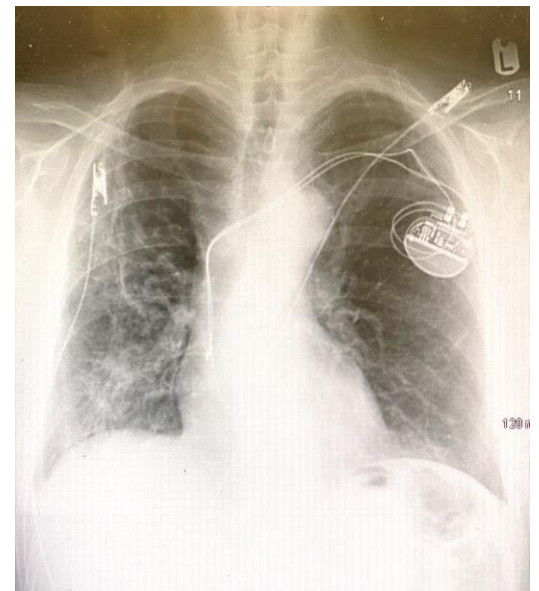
Chest radiograph showing PPM with no complications identified
